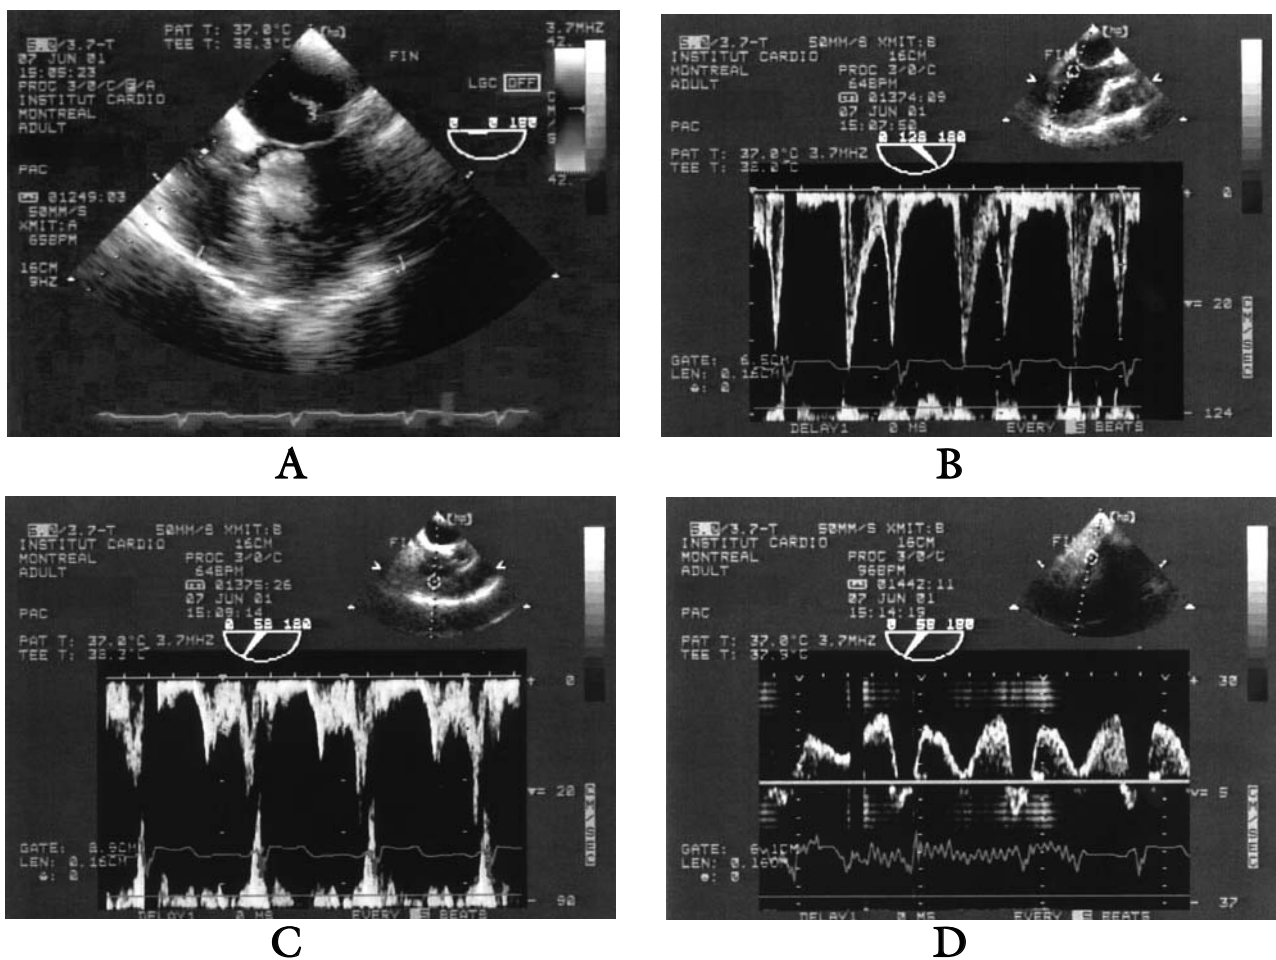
Transesophageal echocardiography findings at the end of surgery. Pulmonary venous flow values were missing. Findings were compatible with normal left diastolic function and persistence of a relaxation abnormality of the right ventricular diastolic function. A) mild-mitral regurgitation; B) mitral flow E and A wave velocities were 91.9 and 82.2 $\text{cm}\cdot\text{sec}^{-1}$ respectively (E/A ratio = 1.14); C) tricuspid flow E and A wave velocities were 29.8 and 43.4 $\text{cm}\cdot\text{sec}^{-1}$ respectively (E/A ratio = 0.69); D) hepatic flow systolic and diastolic wave velocities were 13.7 and 16.8 $\text{cm}\cdot\text{sec}^{-1}$ respectively.
